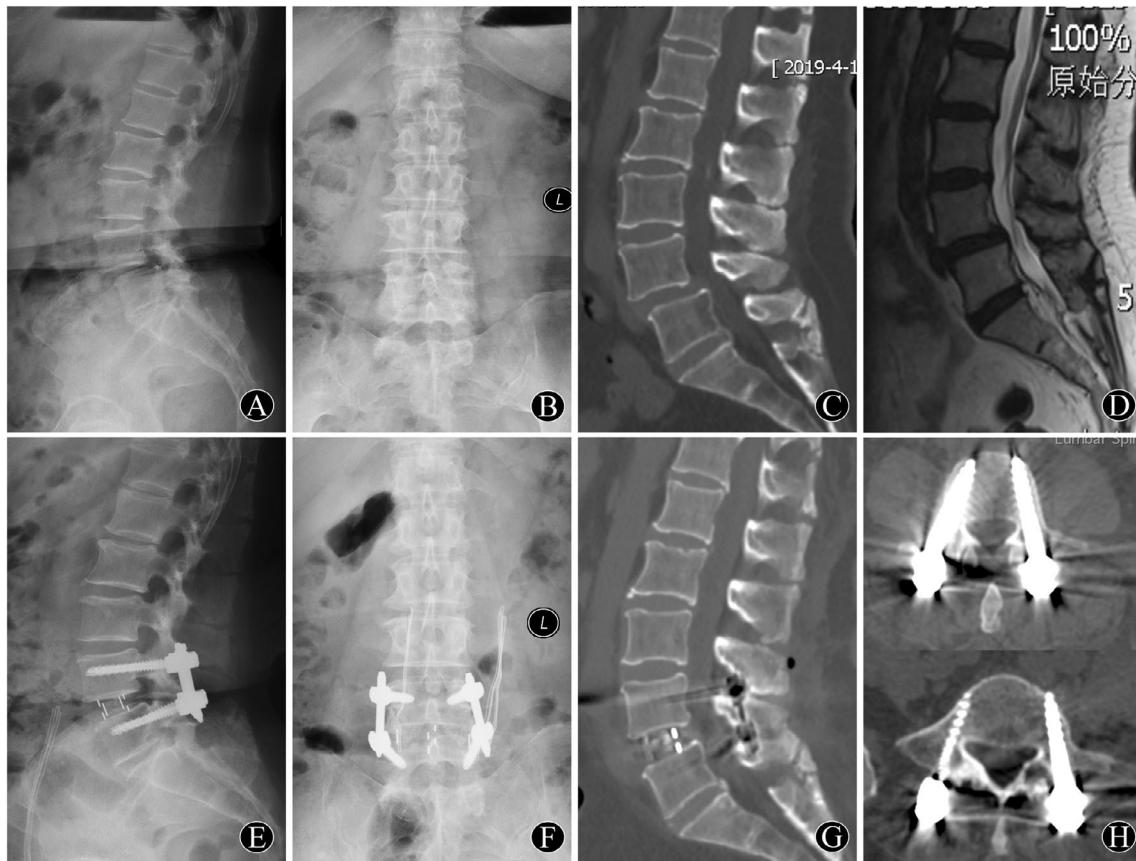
A 66-year-old woman with lumbar degenerative spondylolisthesis ($L_{4/5}$) underwent robot-assisted OLIF surgery. (A, B) Preoperative X-ray films showing lumbar degenerative spondylolisthesis ($L_{4/5}$). (C) Preoperative CT image showing lumbar degenerative spondylolisthesis. (D) Preoperative T2WI sagittal MR image showing spondylolisthesis and spinal canal stenosis. (E, F) One-week postoperative X-ray films showing excellent vertebral reduction and pedicle screw position. (G) One-year postoperative CT image showing interbody fusion has been achieved. (H) One-year postoperative CT transverse images showing the precise position of the pedicle screws.
